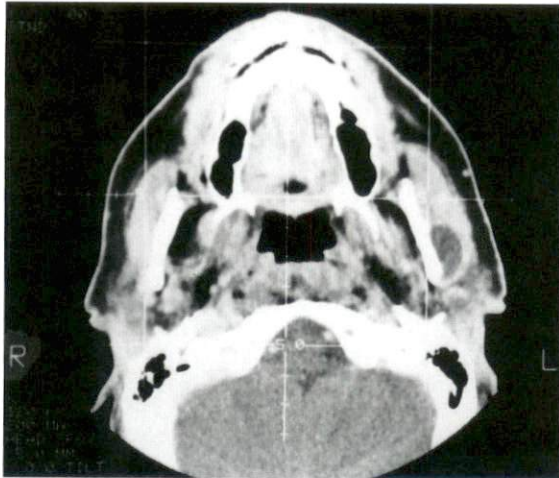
Case 1. The above CT scan shows a left periauricular lesion not involving the parotid gland.
